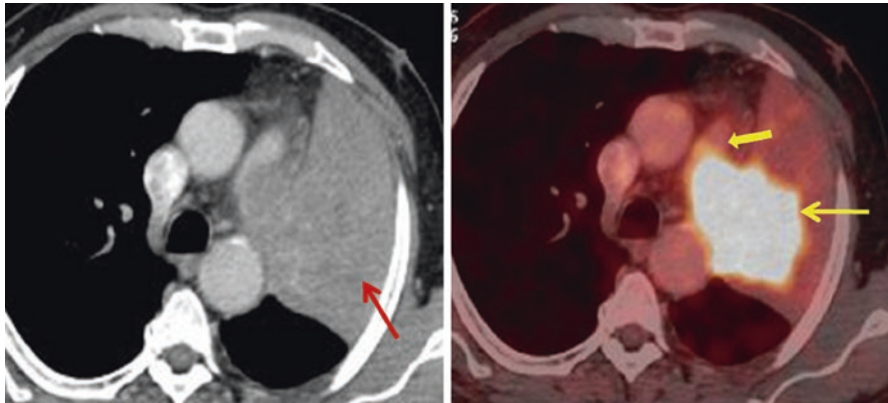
CECT component of the PET/CT showing consolidation/mass (arrow) in upper lobe of the left lung. There is no clear demarcation between the mass and the consolidation making it difficult for radiotherapy planning. A PET/CT image clearly showing the hypermetabolic malignant lung mass (arrow), with surrounding benign consolidation. Invasion of the pulmonary artery (block arrow) is also clearly visible
